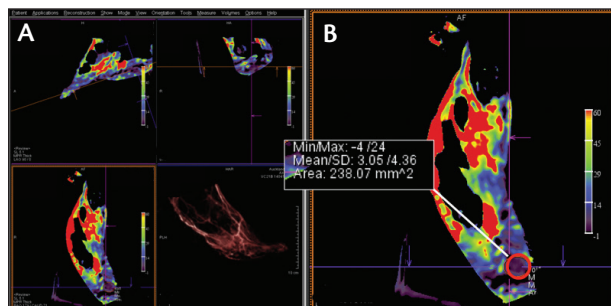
Three-dimensional CT perfusion study of a 78-year-old patient with a heel ulcer prior to revascularization. The workstation allows active scrolling through the 3D data set in axial, coronal, and sagittal planes (A). An ROI measurement of the soft tissues of the heel provides a mean parenchymal blood volume of 3.05 mL of blood per 1,000 mL of tissue (B).
